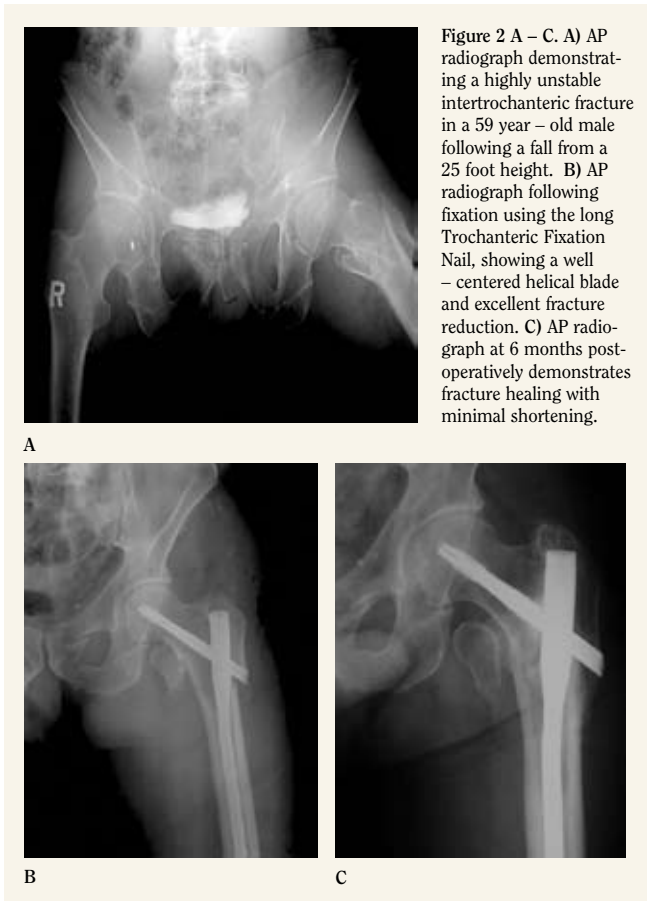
A – C. A) AP radiograph demonstrating a highly unstable intertrochanteric fracture in a 59 year – old male following a fall from a 25 foot height. B) AP radiograph following fixation using the long Trochanteric Fixation Nail, showing a well – centered helical blade and excellent fracture reduction. C) AP radiograph at 6 months postoperatively demonstrates fracture healing with minimal shortening.
